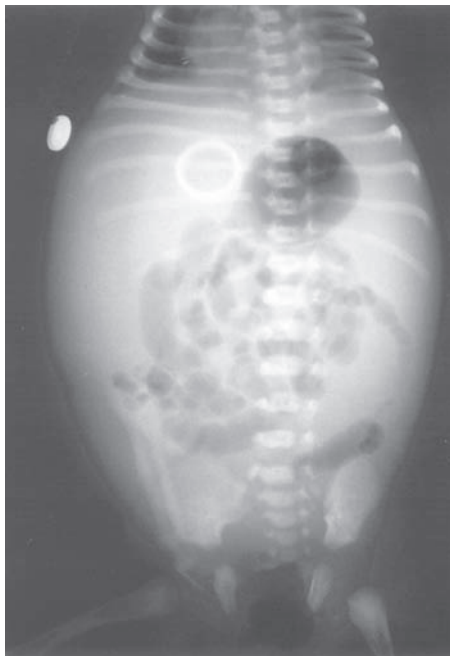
Abdominal X-ray reveals the presence of ascitic fluid in the abdomen.
